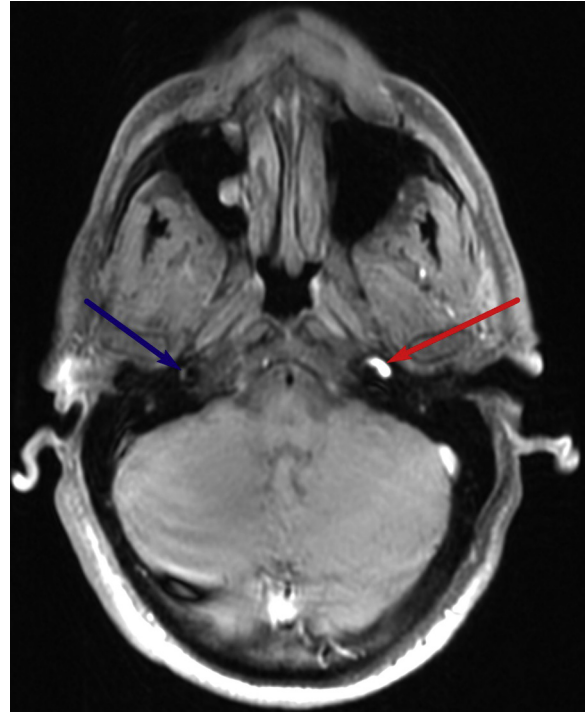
Proximal end of dissection: Axial T1-weighted fat-saturated image through the upper neck demonstrates dissection of the left cervical internal carotid artery, with narrowing of the flow-related signal void starting at 4 cm from the ICA origin. Again seen is a crescentic hyperintense rim (red arrow) surrounding the narrowed flow-related signal void of the cervical ICA, likely representing subacute hemorrhage within the false lumen. The normal right ICA is visualized (blue arrow).
